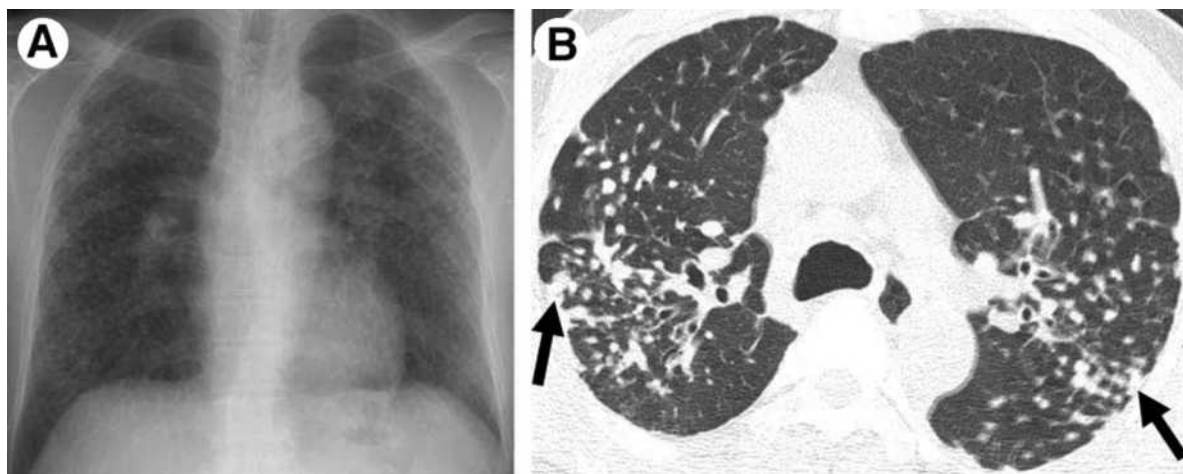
Silicosis in a 56-year-old male who worked in stonecutting for 25 years. (A) Chest radiograph shows multiple variable-sized nodular lesions in both lungs, predominantly in the upper and middle zones. (B) Axial thin-section CT scan (1.0-mm-thick section) obtained at the level of the azygos arch shows multiple small nodules with a perilymphatic (centrilobular plus subpleural) distribution in the upper lobe of both lungs. Note the tendency toward coalescence of the nodules in the lung periphery (arrows). With copyright permission from RSNA and Dr. Kyung Soo Lee (29).
